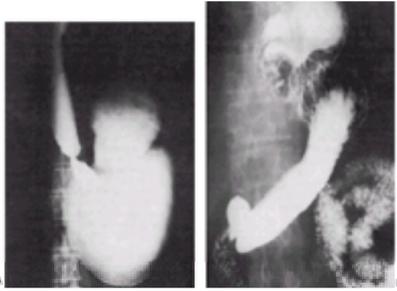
A: Paraesophageal hernia. Note that the esophagogastric junction is located well down in the abdomen and that the fundus rises into the chest. B: Large hiatus hernia. The impression of the diaphragm is seen in the midfundal region. The gastroesophageal junction is located high in the mediastinum. (Radiographs courtesy of C.A. Rohrmann, M.D.)
